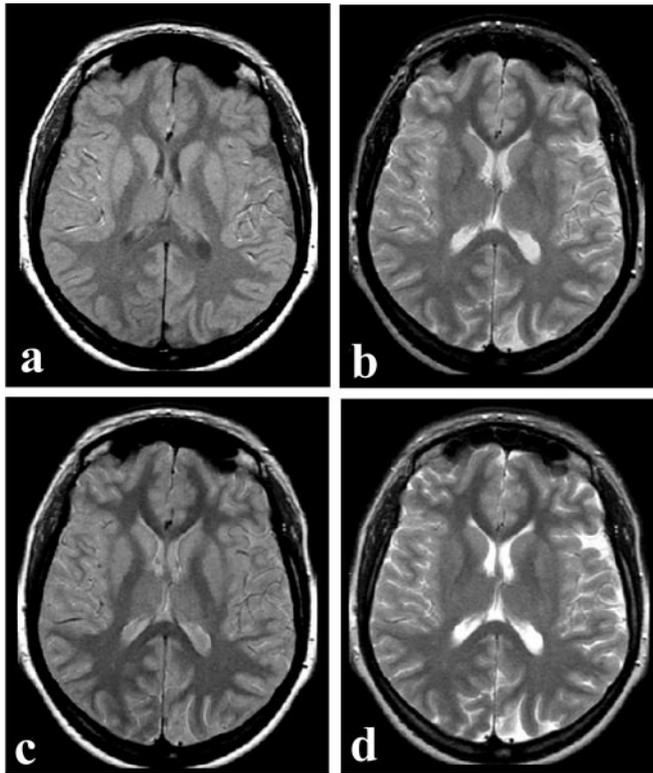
a–d. Difference between CSE and TSE double-echo imaging. a, b An 8-min (TR/TE = 2500/20/80 ms) CSE image acquisition. a Proton-density-weighted image; b T2-weighted image; c, d A 3-min (TR/TE = 3800/22/90 ms) TSE image acquisition [proton-density-weighted (c) and T2-weighted (d) image]. The increase in contrast is due primarily to the selection of a longer TR and due to the MTS effect of the multiple 180° RF pulses used in this multislice acquisition
